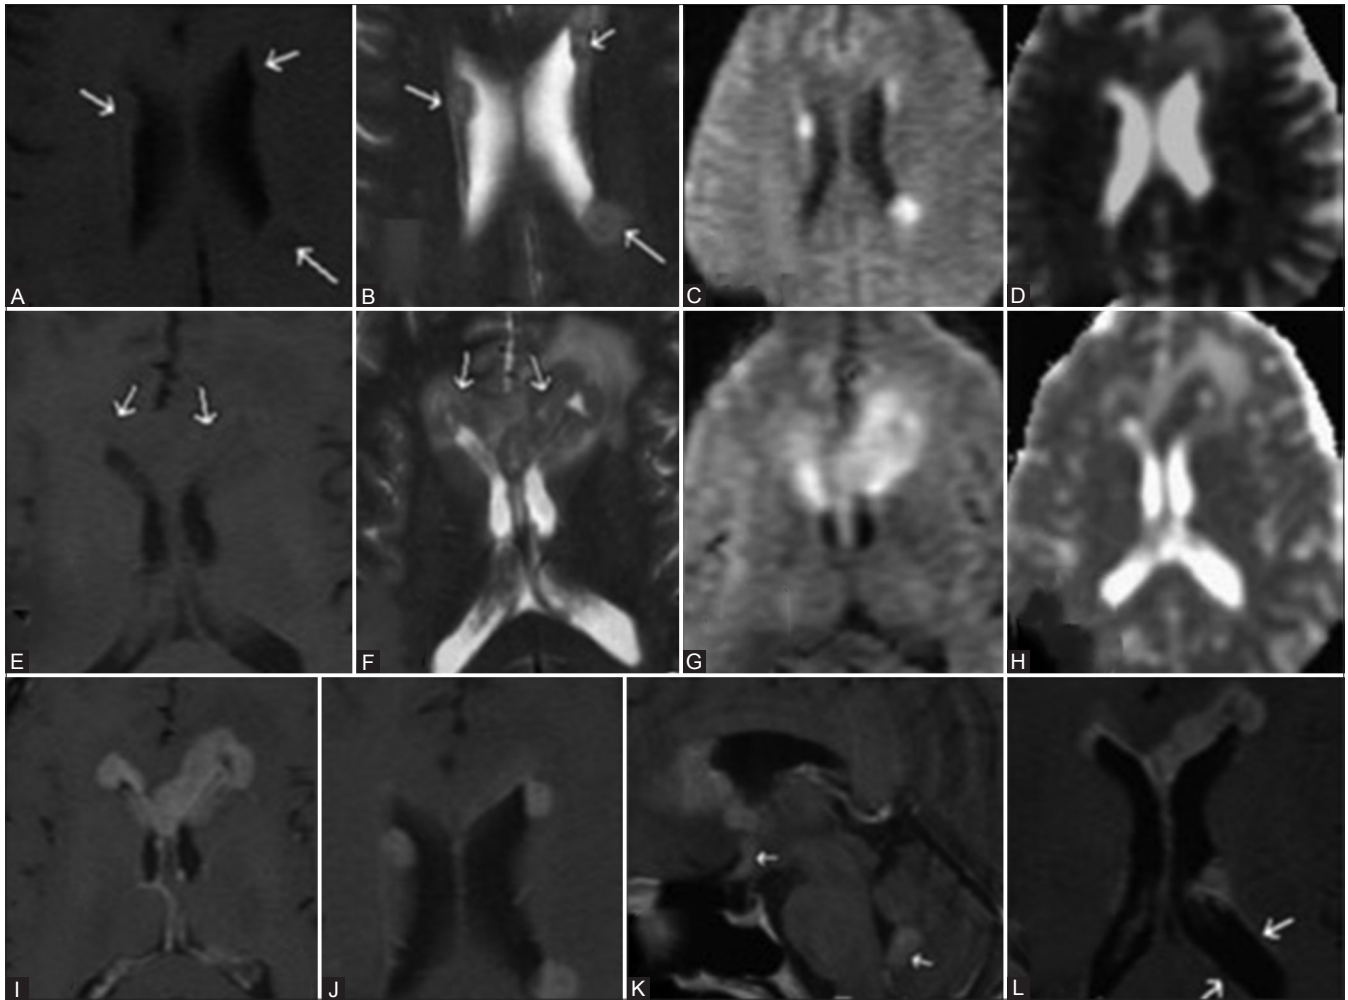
(A-L): History – A 52-year-old male presented with headache for 1 month. MRI showed multiple subependymal nodules isointense on T1W, T2 W images (A and B) along bilateral lateral ventricles with restricted diffusion on diffusion weighted and apparent diffusion coefficient images (C and D). There was also a lesion involving corpus callosum (arrows), isointense on T1 (E) and hypointense on T2 (F) with restricted diffusion on diffusion weighted and apparent diffusion coefficient images (G and H). Homogenous enhancement of the corpus callosal lesion and subependymal nodules noted on post-contrast T1 W images (I and J). Furthermore, post-contrast T1 W images (K and L) revealed enhancing lesions involving hypothalamus, cerebellar vermis (arrows in K) and subependymal enhancement (arrows in L) along the lateral ventricles
